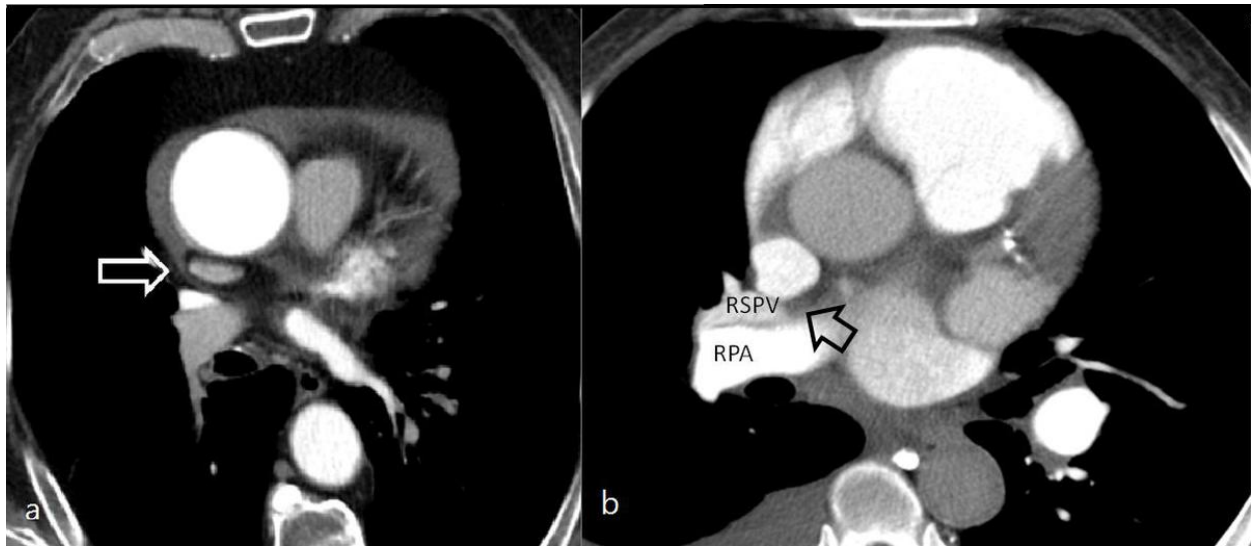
Axial CT images showing the postcaval recess, a diverticulum of the pericardial cavity proper (white arrow in a))that extends behind and along the right lateral aspect of the superior vena cava. b) The postcaval recess is bounded by the right pulmonary artery (RPA) and the right superior pulmonary vein (RSPV)(black arrow).
